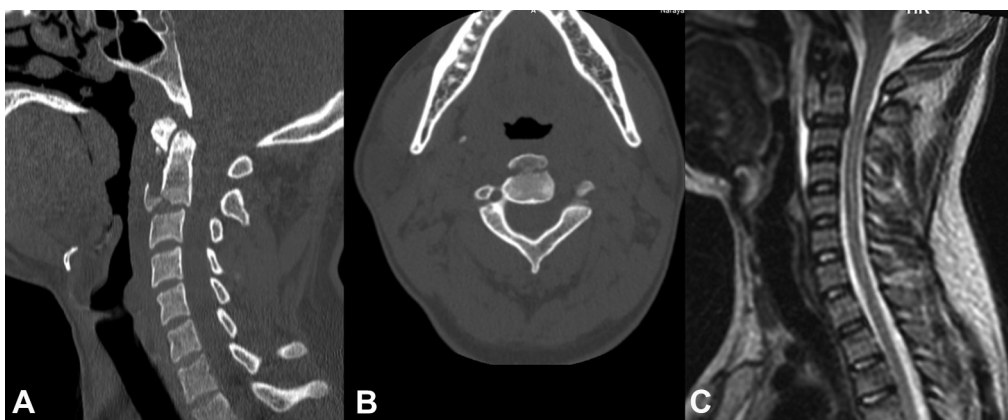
(A and B) CT scan cervical spine showing details of the fracture and (C) MRI showing presence of pre-vertebral hematoma.
